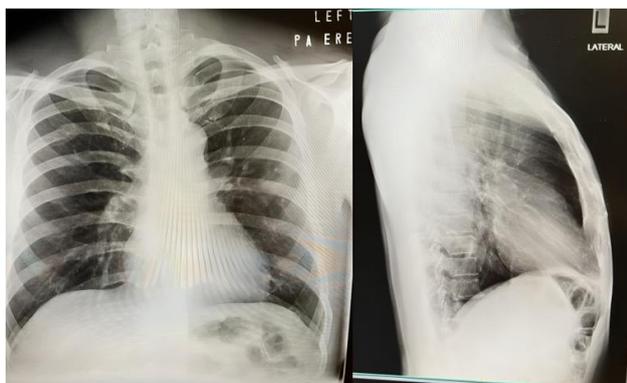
Chest X-ray showed nodular and linear opacities in the left midzone, accompanied by reticulonodular changes in both lower zones: PA view (left) & lateral view (right) (Reprinted with permission of the patient)
